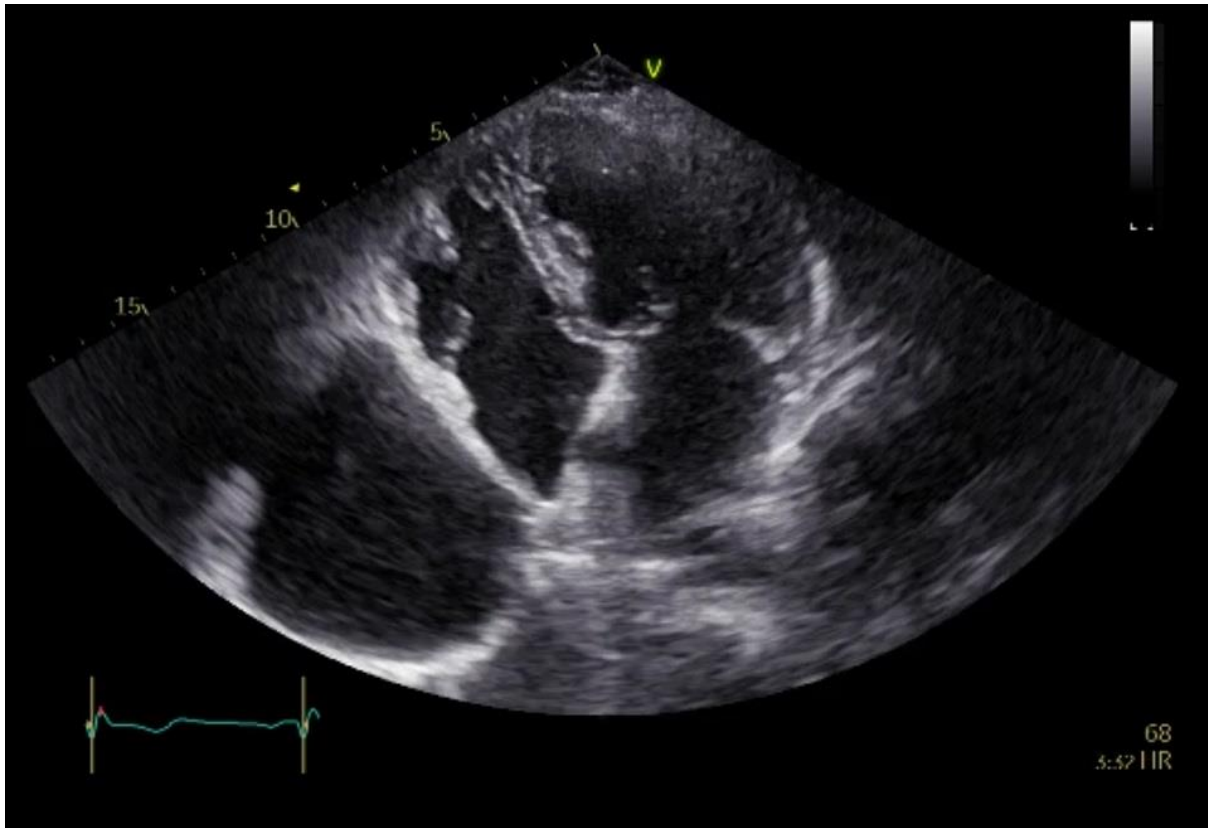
Transthoracic echocardiography (TTE), 4-chamber view, showing a fluid filled lesion near the right atrium.*
